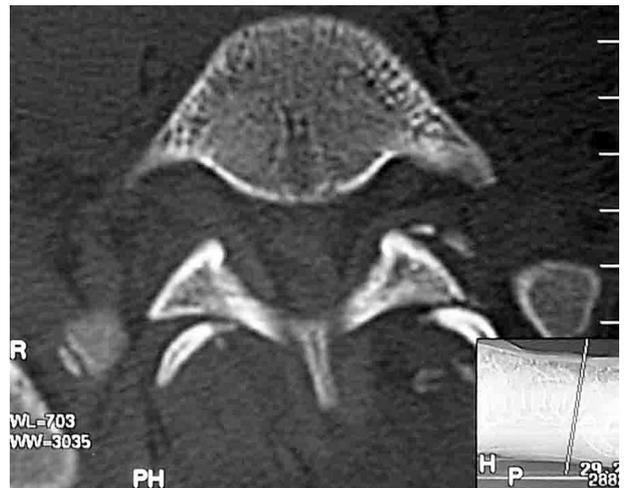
Computed tomography (CT) shows bilateral facet dislocation, so-called 'naked' facet sign, with an anterior displacement of L5 on S1 and small particles of bone on the left side.
